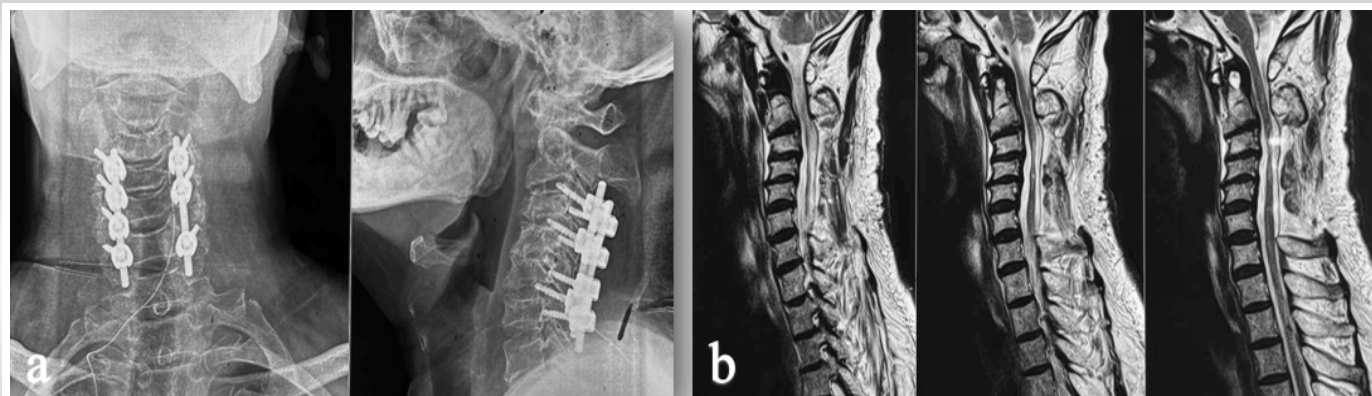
Post-operative imaging following C3–C6 laminectomy and posterior cervical fusion. (a) Anteroposterior and lateral radiographs demonstrating stable posterior instrumentation and maintained cervical alignment. (b) Sagittal T2-weighted magnetic resonance images demonstrating successful decompression of the cervical spinal cord with expansion of the spinal canal and improved cerebrospinal fluid signal surrounding the cord.
